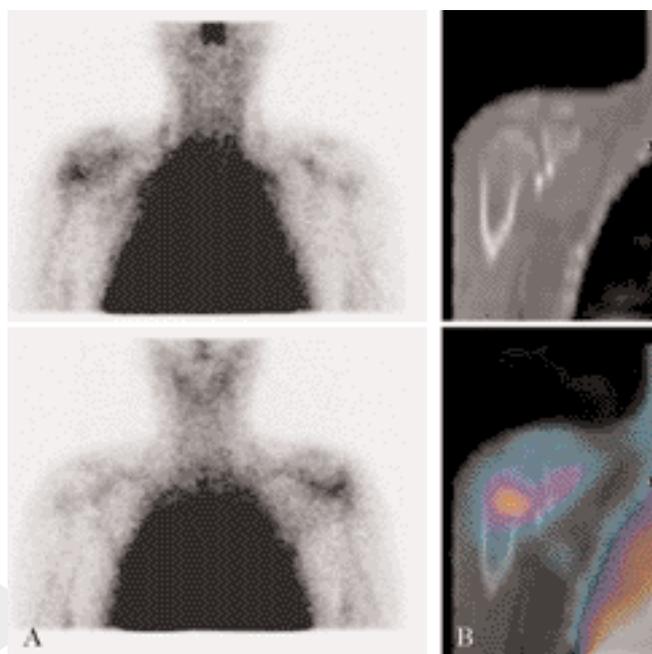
^{99m}Tc -HMPAO-labeled WBC scintigraphy of a 45-year-old man in whom post-traumatic osteomyelitis of right scapulo-humeral bones was suspected. A) Twenty-four hours planar images (top: anterior view; bottom: posterior view) show diffusely increased tracer uptake in the right shoulder. B) SPET/CT (bottom, coronal view) accurately localizes this WBC uptake in the right caput humeri; the corresponding CT scan is on the top. WBC: white blood cells; SPET: single photon emission tomography; CT: computed tomography.
